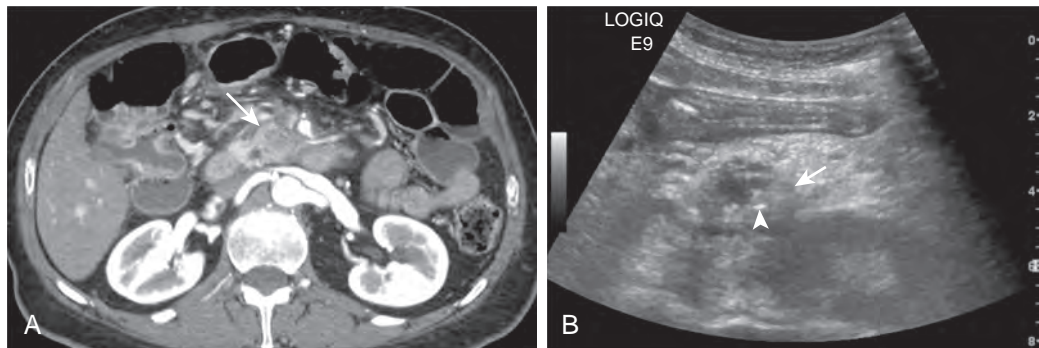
Images of a 64-year-old woman with vague upper abdominal pain and weight loss. A. Preliminary axial CT scan with contrast material revealed a pancreatic head mass (arrow). B. This mass (arrow) was subsequently biopsied percutaneously under ultrasound guidance by an anterior approach. The needle tip (arrowhead) is placed directly in this soft tissue. Fine-needle aspiration revealed adenocarcinoma. There were no hemorrhagic complications, and real-time guidance prevented transgression of the artery.
